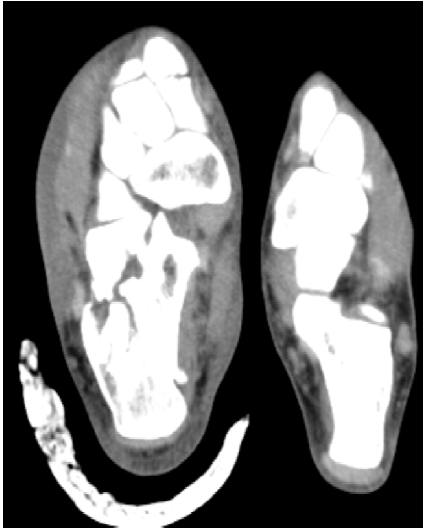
CT scan Sander's type2
